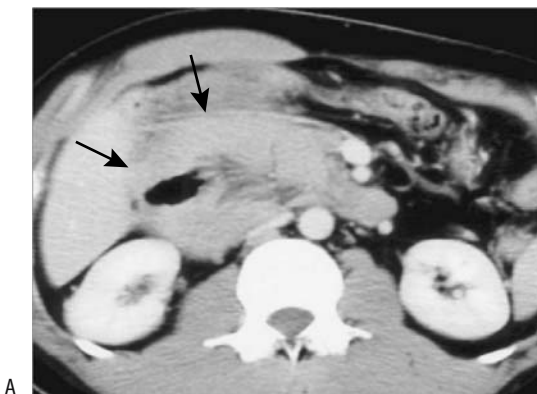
Right paraduodenal hernia. A: Postcontrast CT reveals focal small bowel loops in the right paraduodenal region (arrows) (Waldeyer fossa). (Source: Okino Y, Kiyosue H, Mori H, et al. Root of the small bowel mesentery: correlative anatomy and CT features of pathologic conditions. *Radiographics* 2001;21:1475–1490, with permission from the Radiological Society of North America.) B: Right paraduodenal hernia and midgut malrotation in another patient.
